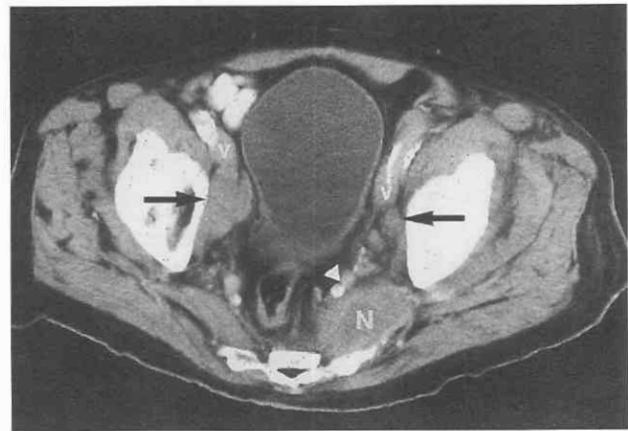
Pelvic lymph nodes. CT scan through the sciatic notch shows bilateral obturator lymph node metastases (*arrows*) from recurrent prostate cancer posterior to the external iliac veins (*v*) and a larger left internal iliac node metastasis (*N*) confluent with the piriformis muscle and posterior to the left internal iliac pedicle (*arrowheads*).
